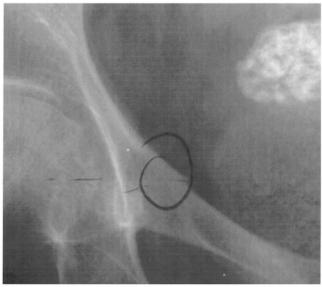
(a) A-P X-ray of the lower lumber spine and pelvis showing extensive discogenic and vertebral body degeneration with scoliosis to the left, osteophytes and endplate abnormalities on the left. (b)
